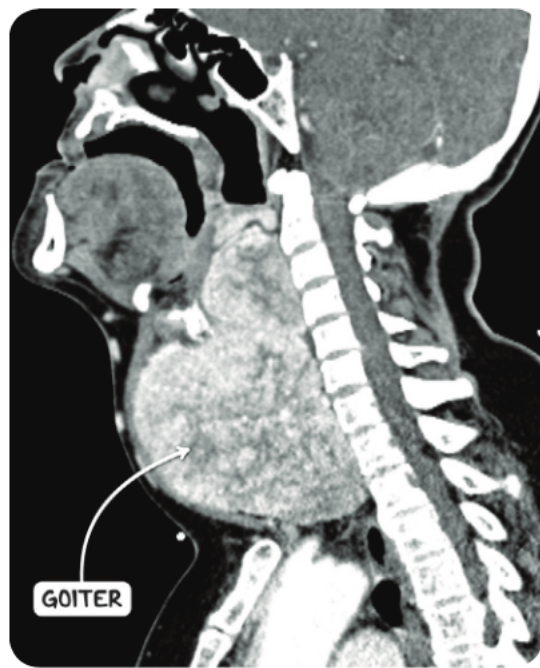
A CT scan of the head and neck in the sagittal plane demonstrating a massive goiter extending from the mandible to the suprasternal notch.
